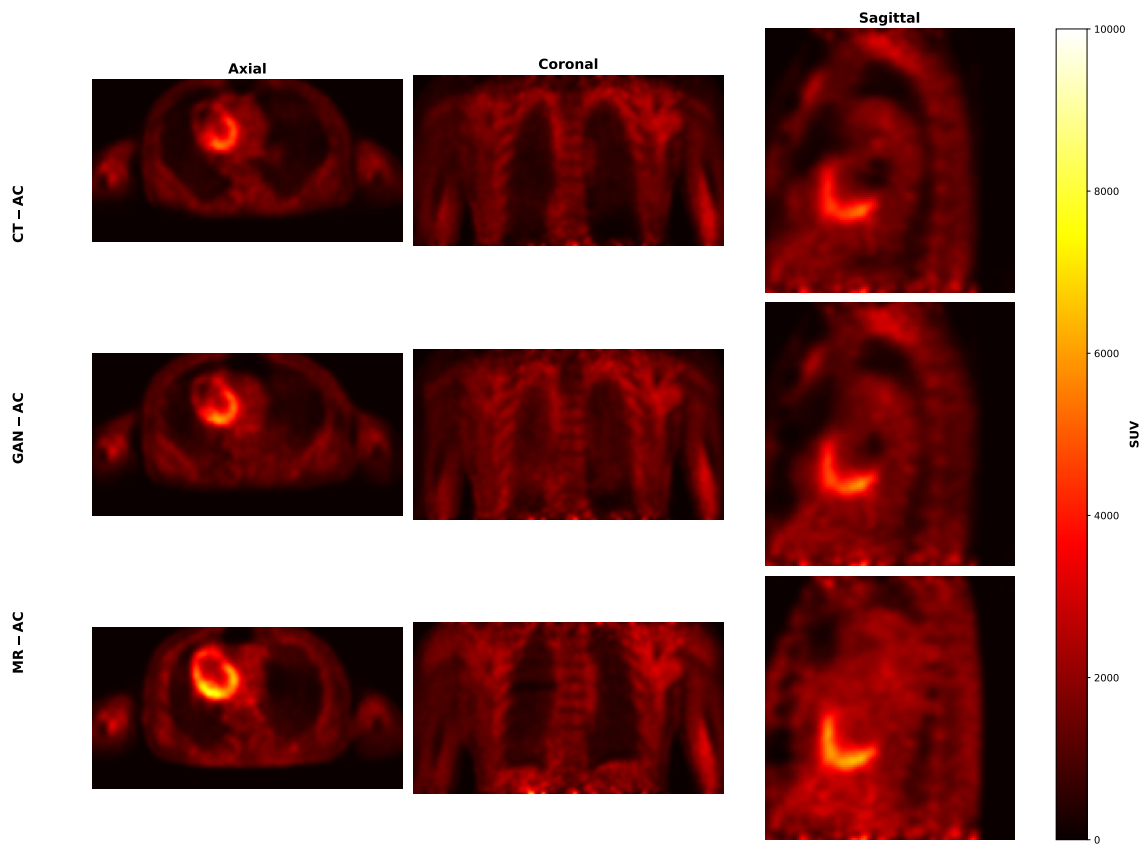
PET slices for subject 019 in axial, coronal, and sagittal views, reconstructed using different AC methods: CT-AC (Reference), GAN-AC, and MR-AC.
